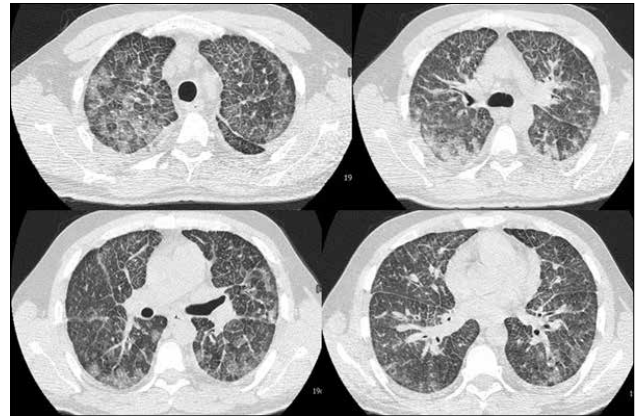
High Resolution Computed Tomography; bilateral ground-glass opacity and prominence of interlobular septum
